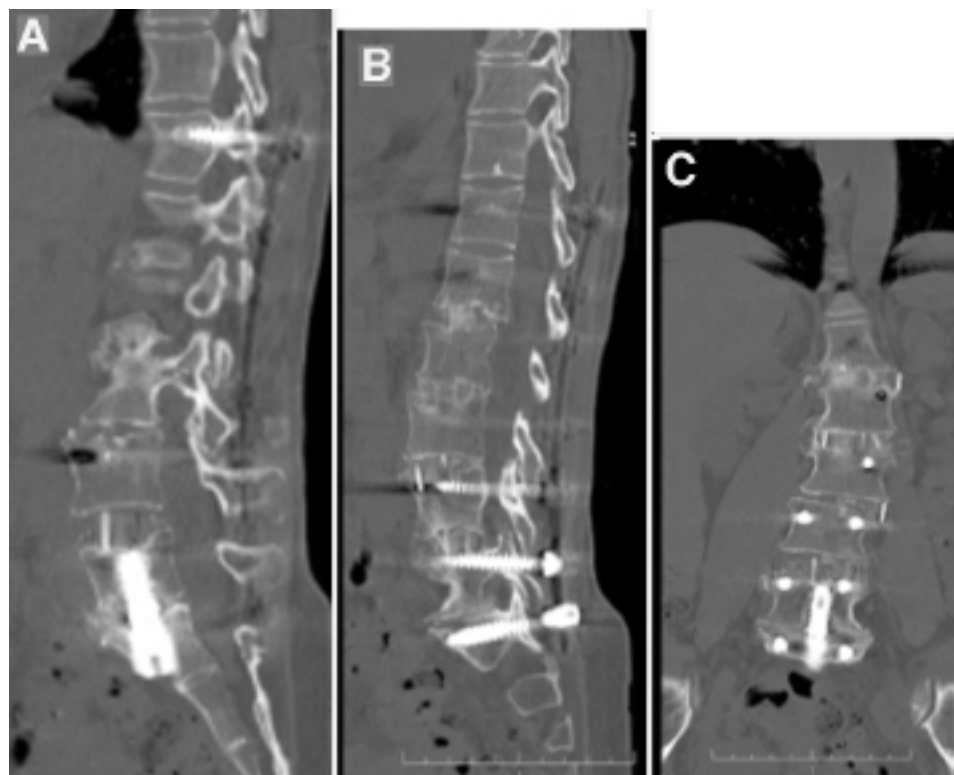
Postoperative CT scans, sagittal (A and B) and coronal (C) reconstruction images, demonstrating a solid arthrodesis.
